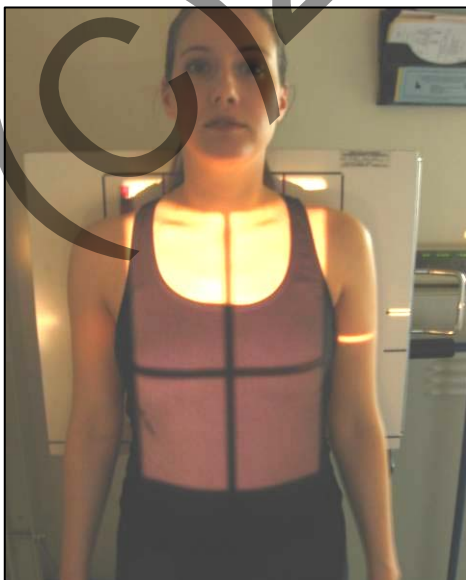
Standing patient position for AP thoracic spine radiographic view.
